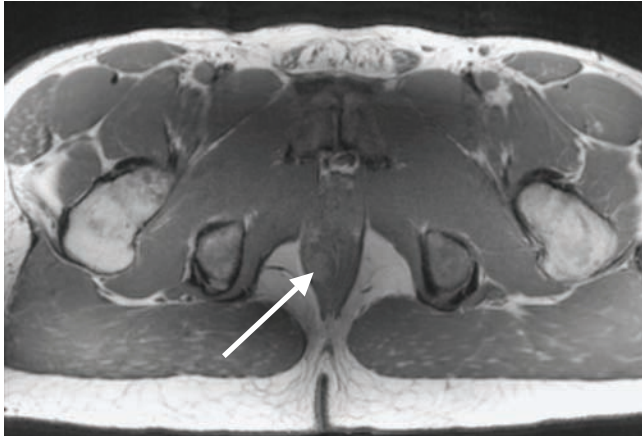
MRI image of gastrointestinal stromal tumor (GIST) along right posterolateral rectal wall (arrow).
